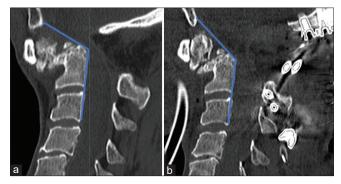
CT scan, bone window, sagittal views. (a) Preoperative imaging. (b) Immediate post-operative imaging. Notice the realignment and decompression obtained, highlighted by the blue angled lines.
